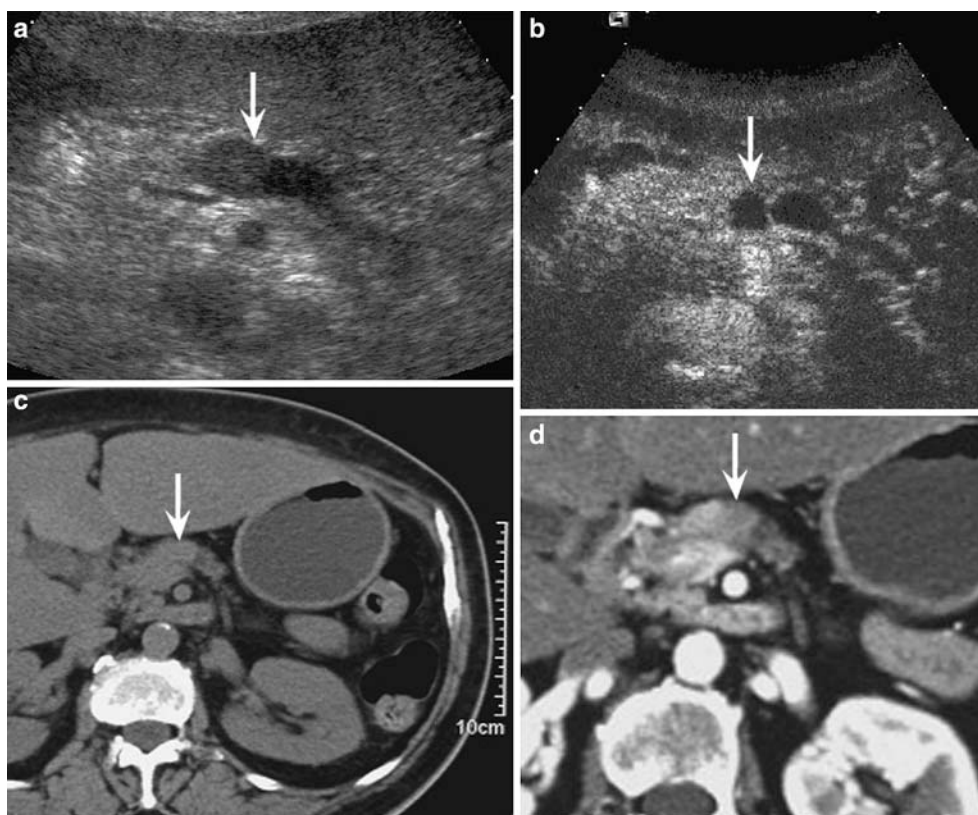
Pancreatic adenocarcinoma. Transverse US scans (A) pre- and (B) post-contrast medium injection identify a small pancreatic adenocarcinoma (*arrow*) with good conspicuity with respect to the normal pancreatic parenchyma. CT scans (C) pre- and (D) post-contrast medium injection show the lesion (*arrow*) with less conspicuity than US examinations.
